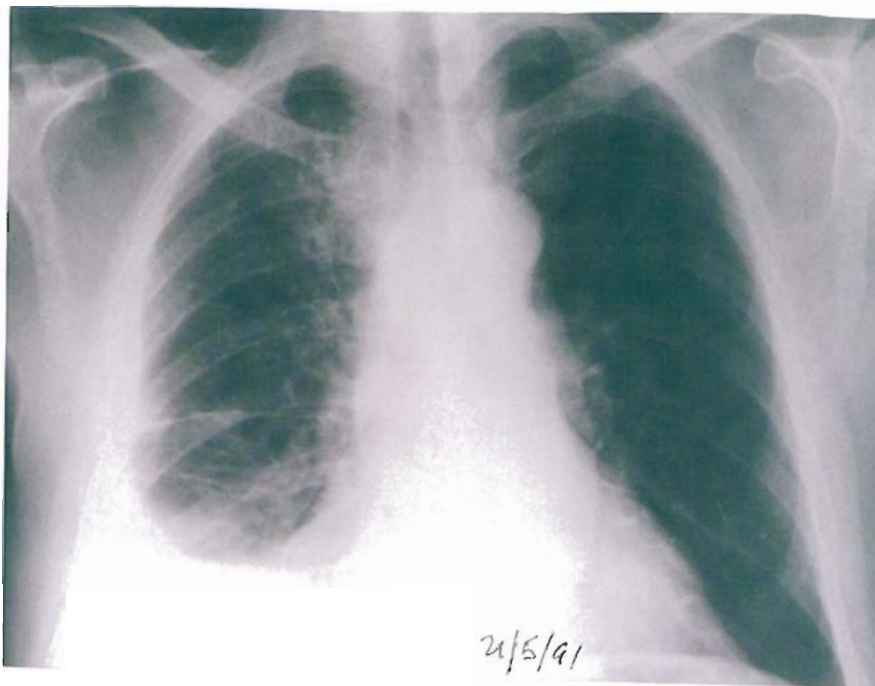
A seven month history, diagnosed in May 1991, this x-ray was taken 21 May 1991. Given a course of treatment.
